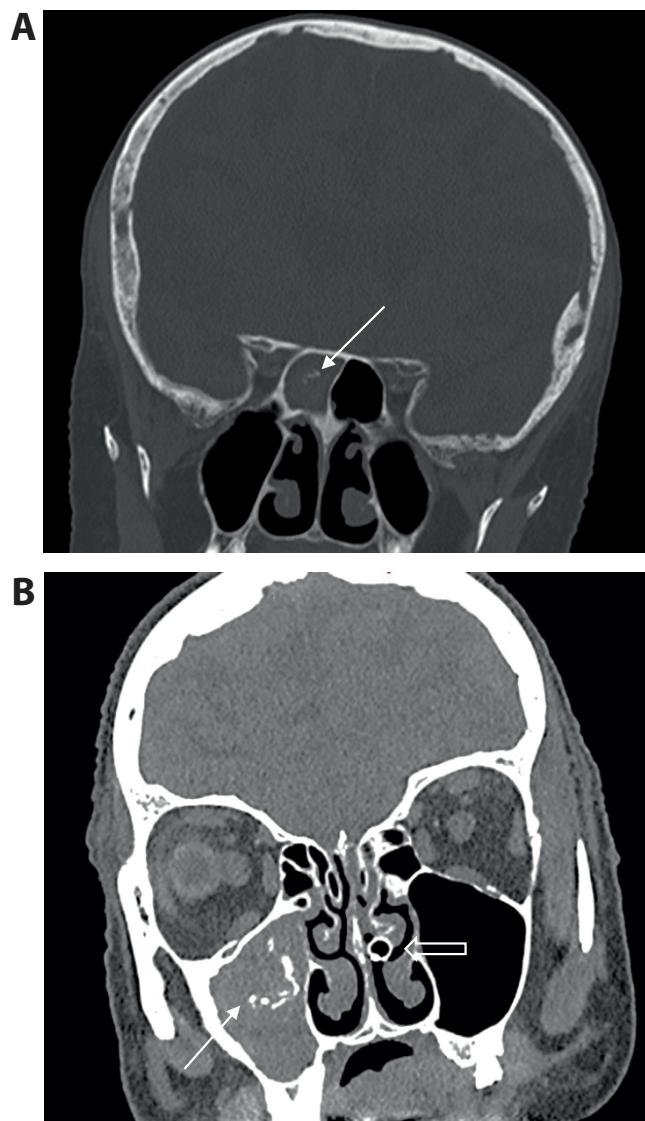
Characteristic findings in coronal CT scans of right sphenoid sinus FB (A) and right maxillary sinus FB (B). The figure presents a coronal CT scan of a patient with right sphenoid sinus FB (A), and of another patient with maxillary sinus FB (B). The radiological findings include complete sinus opacification, intrasinus calcifications (arrow), and sinus walls sclerosis. A nasogastric tube (open arrow) is seen in the left nasal cavity (B).
